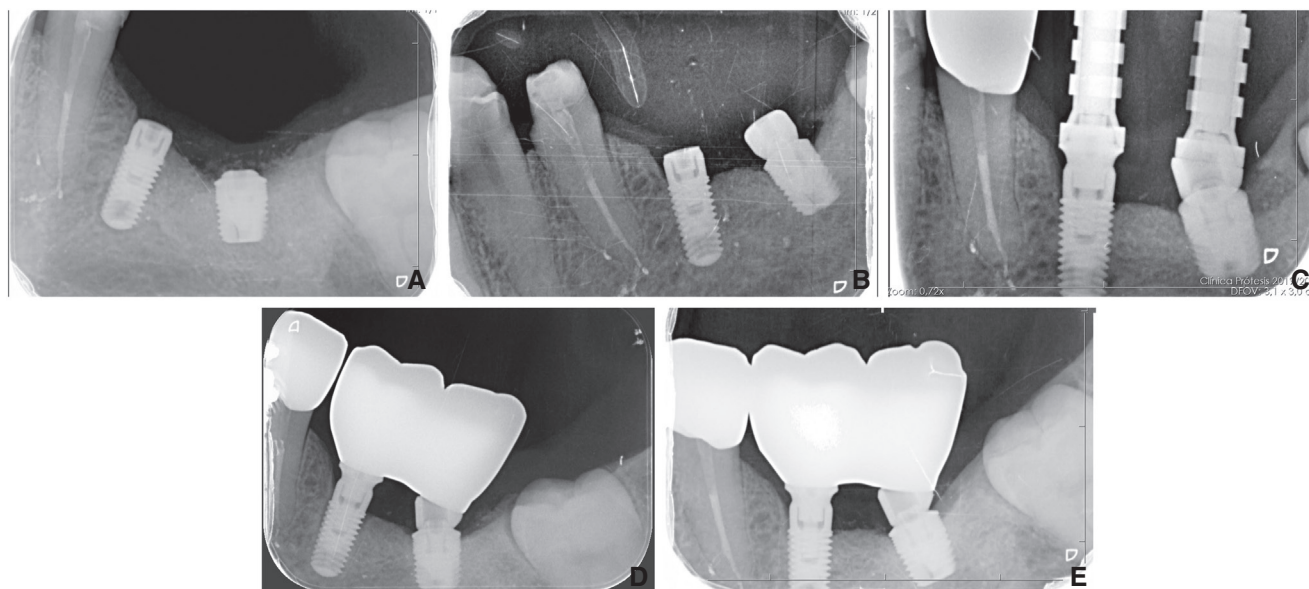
Radiographic images of 2 representative short internal connection implants. A, After implant placement. B, 3 months after implant placement. C, 6 months after implant placement. D, 12 months after implant placement. E, 24 months after implant placement.
